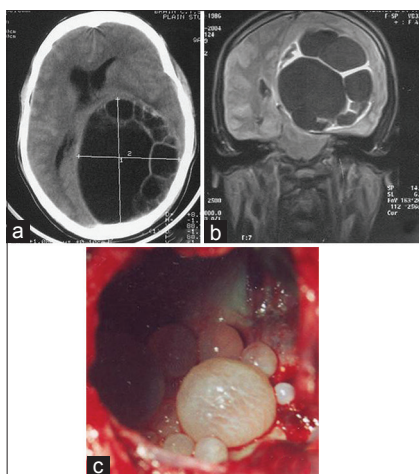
(a) Plain computed tomography scan of brain, axial view: Showing a large multi-cystic lesion in left parieto-occipital region with mass effect. (b) Plain magnetic resonance imaging scan of brain T1, coronal view: Showing a large multi-cystic lesion in left parieto-occipital region with mass effect. (c) Intraoperative findings confirm multiple daughter cysts inside a large cyst
